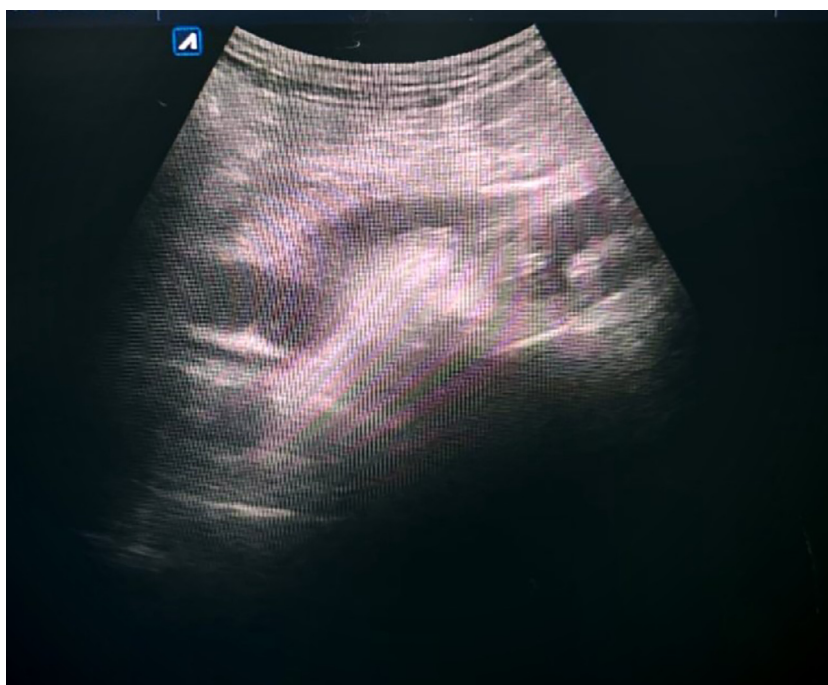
Ultrasound of the right kidney and upper ureteric region demonstrated 2 discontinued segments of DJ stent.
